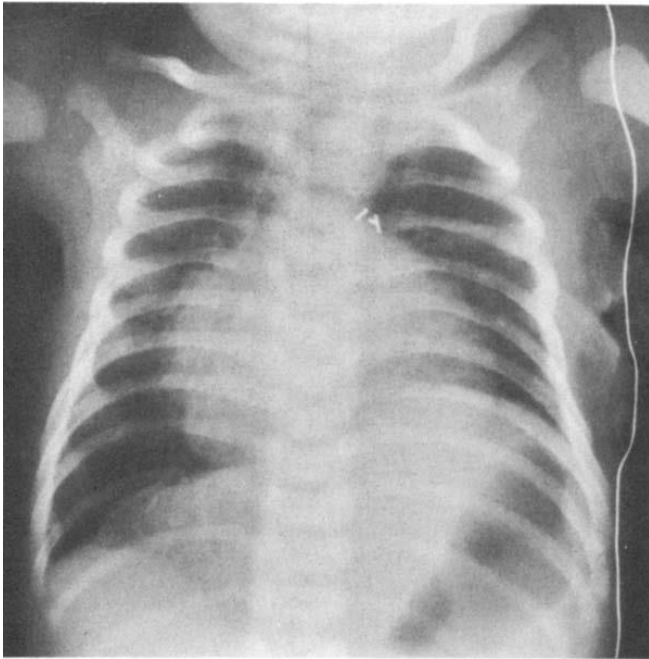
Chest X-ray with elevation of the left hemidiaphragm
